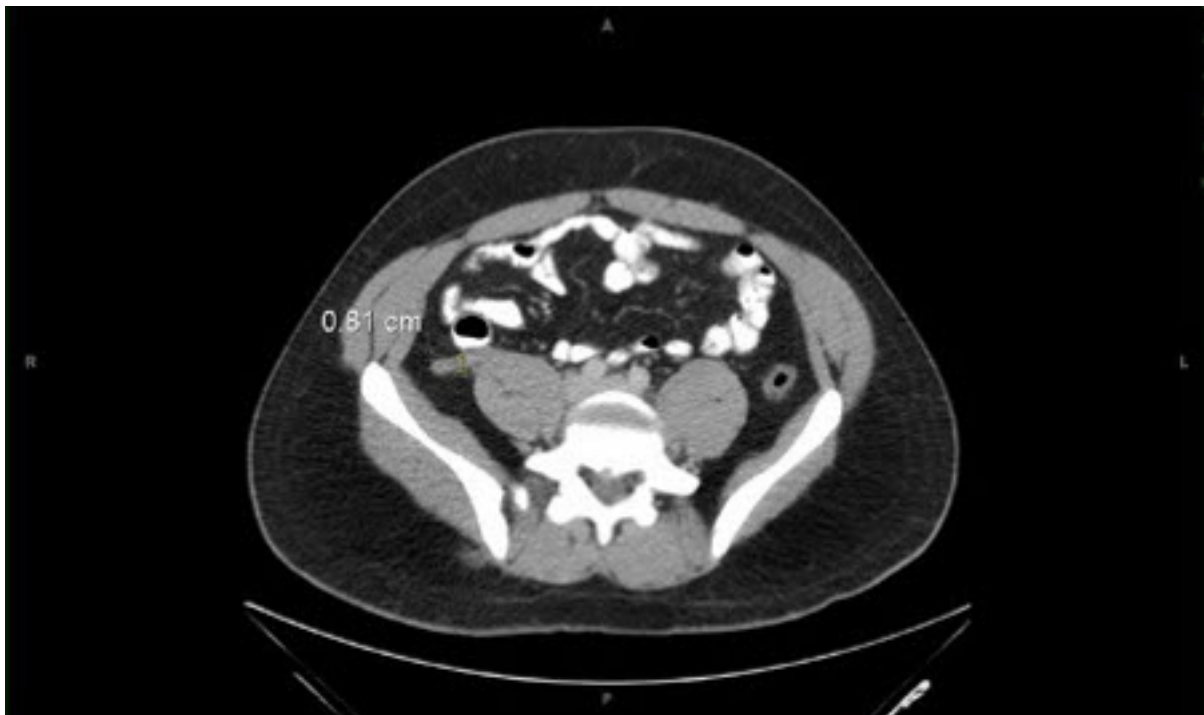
Appendicitis: CT abdomen showing thickened appendix
